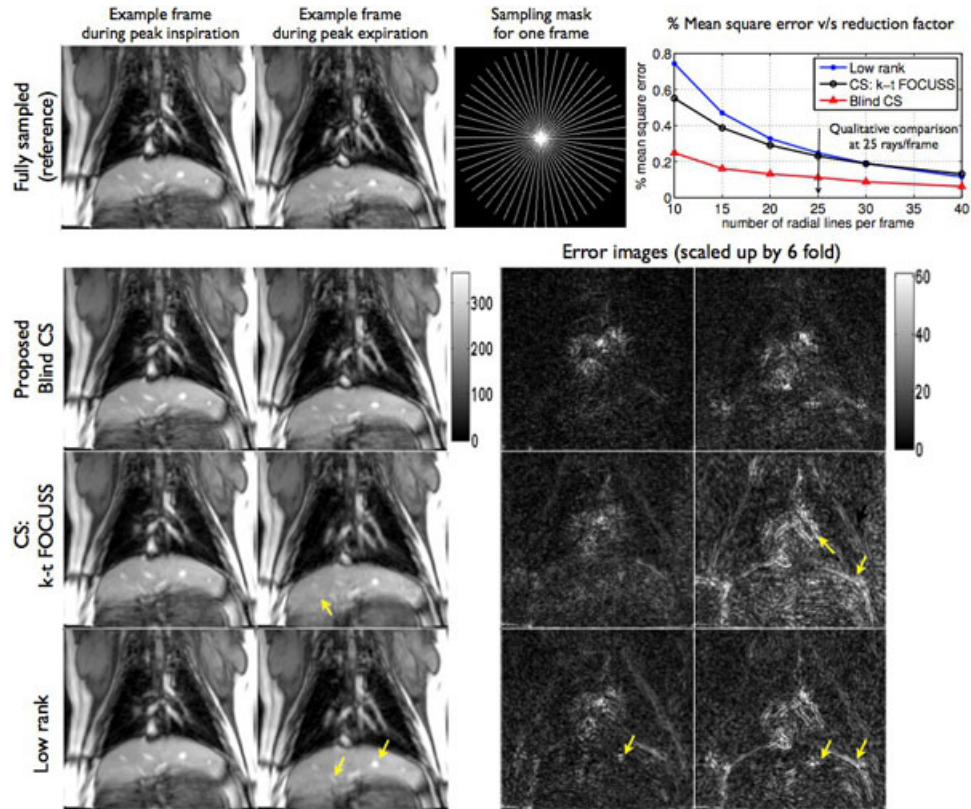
Performance evaluation of undersampled reconstruction of a dynamic lung MRI dataset using the blind compressed sensing (BCS), CS and low rank schemes: It can be seen that the BCS scheme consistently produce the least mean square error at all undersampling factors. The CS, and low rank schemes depict loss in spatial features, and compromises due to motion blurring (see the yellow arrows in rows 3,4). In contrast, the BCS scheme was found to be more robust to motion blur, and provided superior spatio-temporal fidelity.
